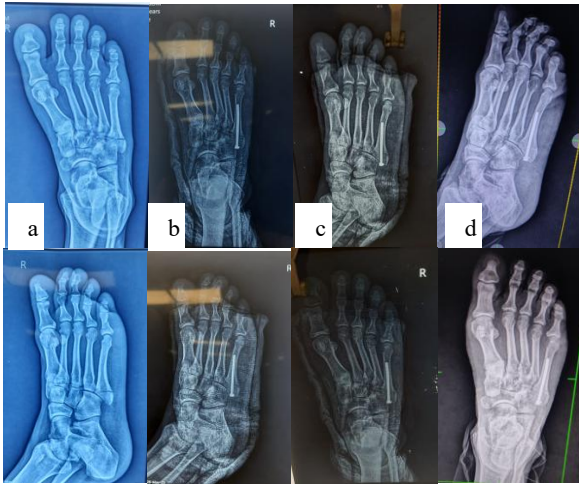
Patient's X-rays. (a) At presentation (b) After Op (c) Post 6 weeks (d) Post 12 weeks.
